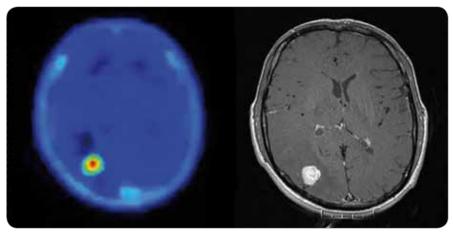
Example of FLT-PET. Solitary metastasis in brain, right occipital lobe, in a patient with thigh soft tissue sarcoma. Left image: FLT – PET, right image: brain MRI. No clinical symptoms.
